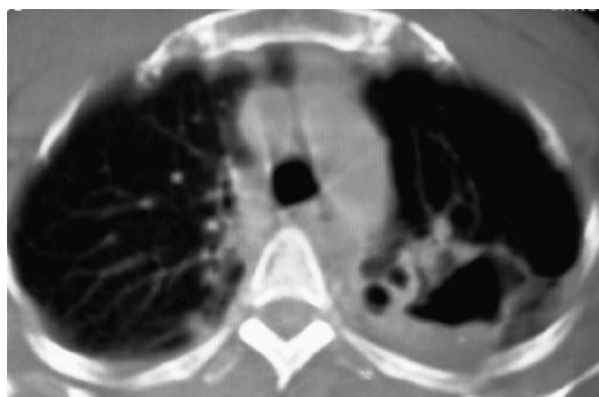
Computed tomography scan of thorax showed thick-walled cavity involving apicoposterior segment of left upper lobe.
